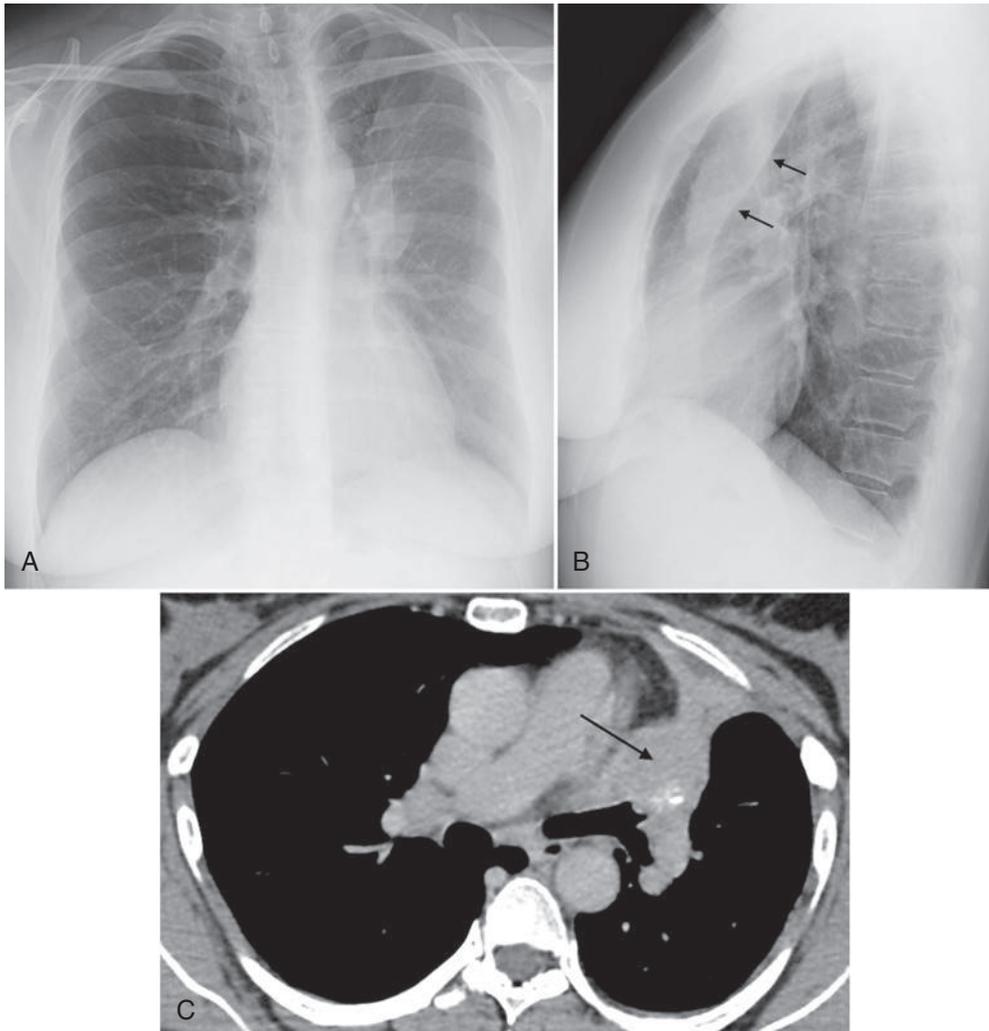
A, Posteroanterior view of the chest shows leftward mediastinal shift, a left hilar mass, and increased density overlying the left chest. B, Lateral view shows a wedge of increased density (arrows) anteriorly with its apex at the hilum and its base on the pleural surface representing the collapsed left upper lobe. C, Computed tomography image shows a partially calcified left hilar mass (arrow), with the collapsed left upper lobe distally. Biopsy of the mass revealed carcinoid tumor.
